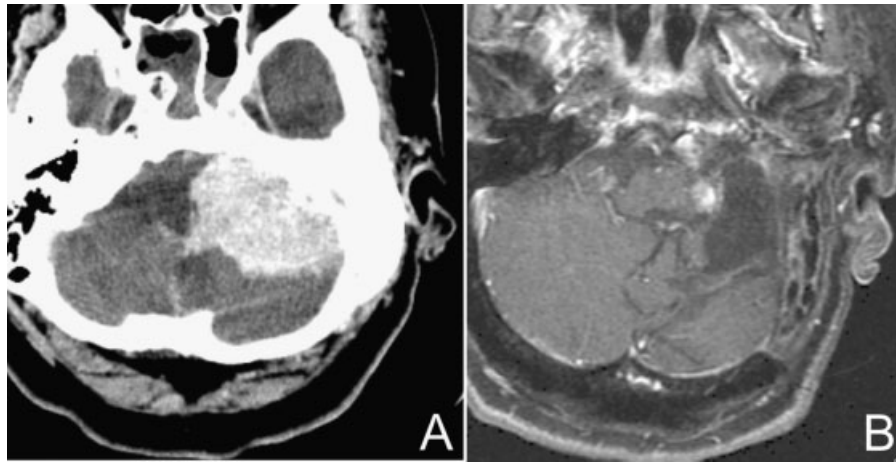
(A) Axial computed tomography images demonstrating a large (6.5 cm maximum diameter) left-sided skull base lesion resulting in considerable posterior fossa compression of the brainstem and cerebellum. (B) Postoperative axial T1-weighted magnetic resonance images with gadolinium enhancement demonstrating subtotal resection and posterior fossa neural decompression.
